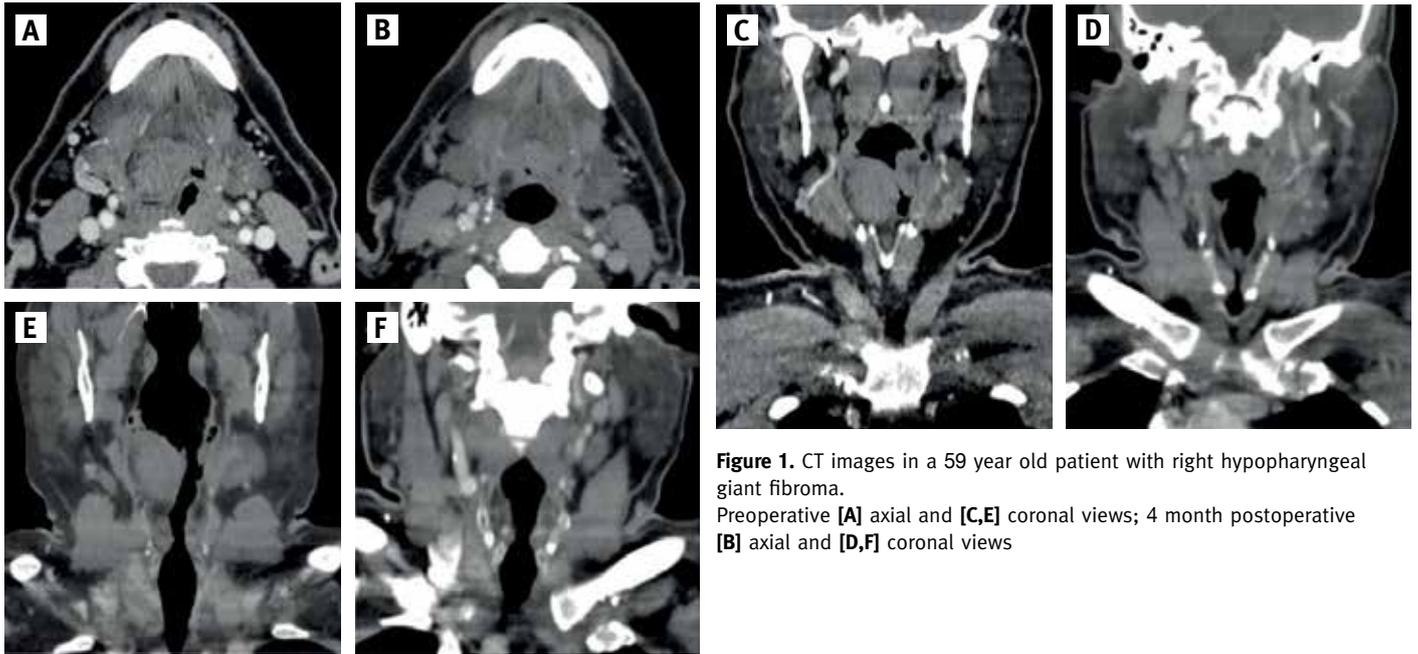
CT images in a 59 year old patient with right hypopharyngeal giant fibroma. Preoperative [A] axial and [C,E] coronal views; 4 month postoperative [B] axial and [D,F] coronal views
